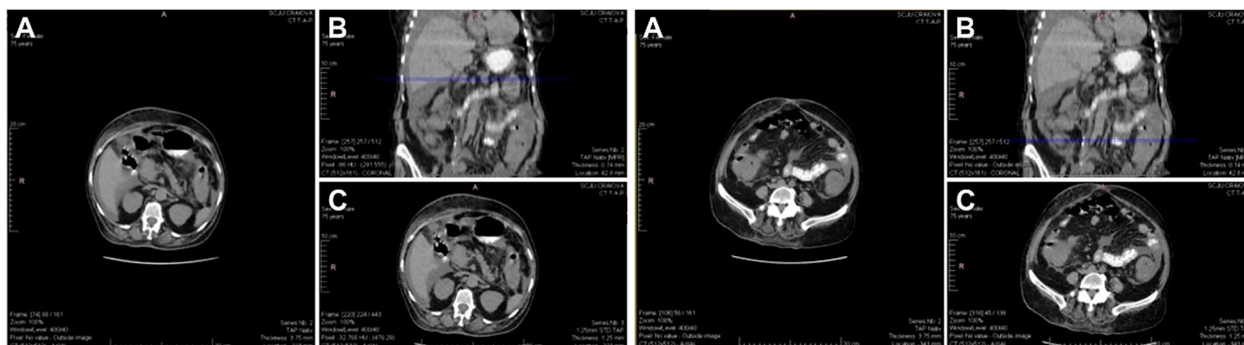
(A–C) Abdominal CT: peritoneal fluid in moderate amount, perihepatic, perisplenic display.
